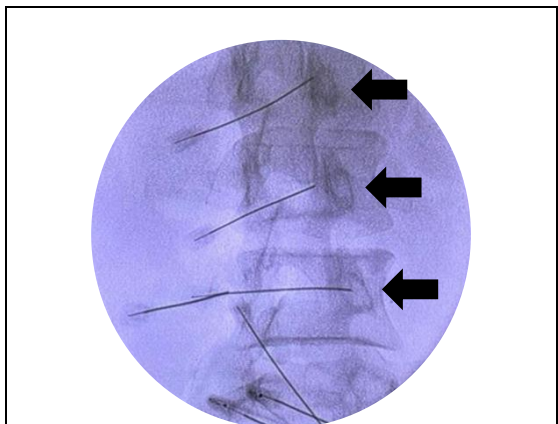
Oblique projection radiography of the lumbosacral column
